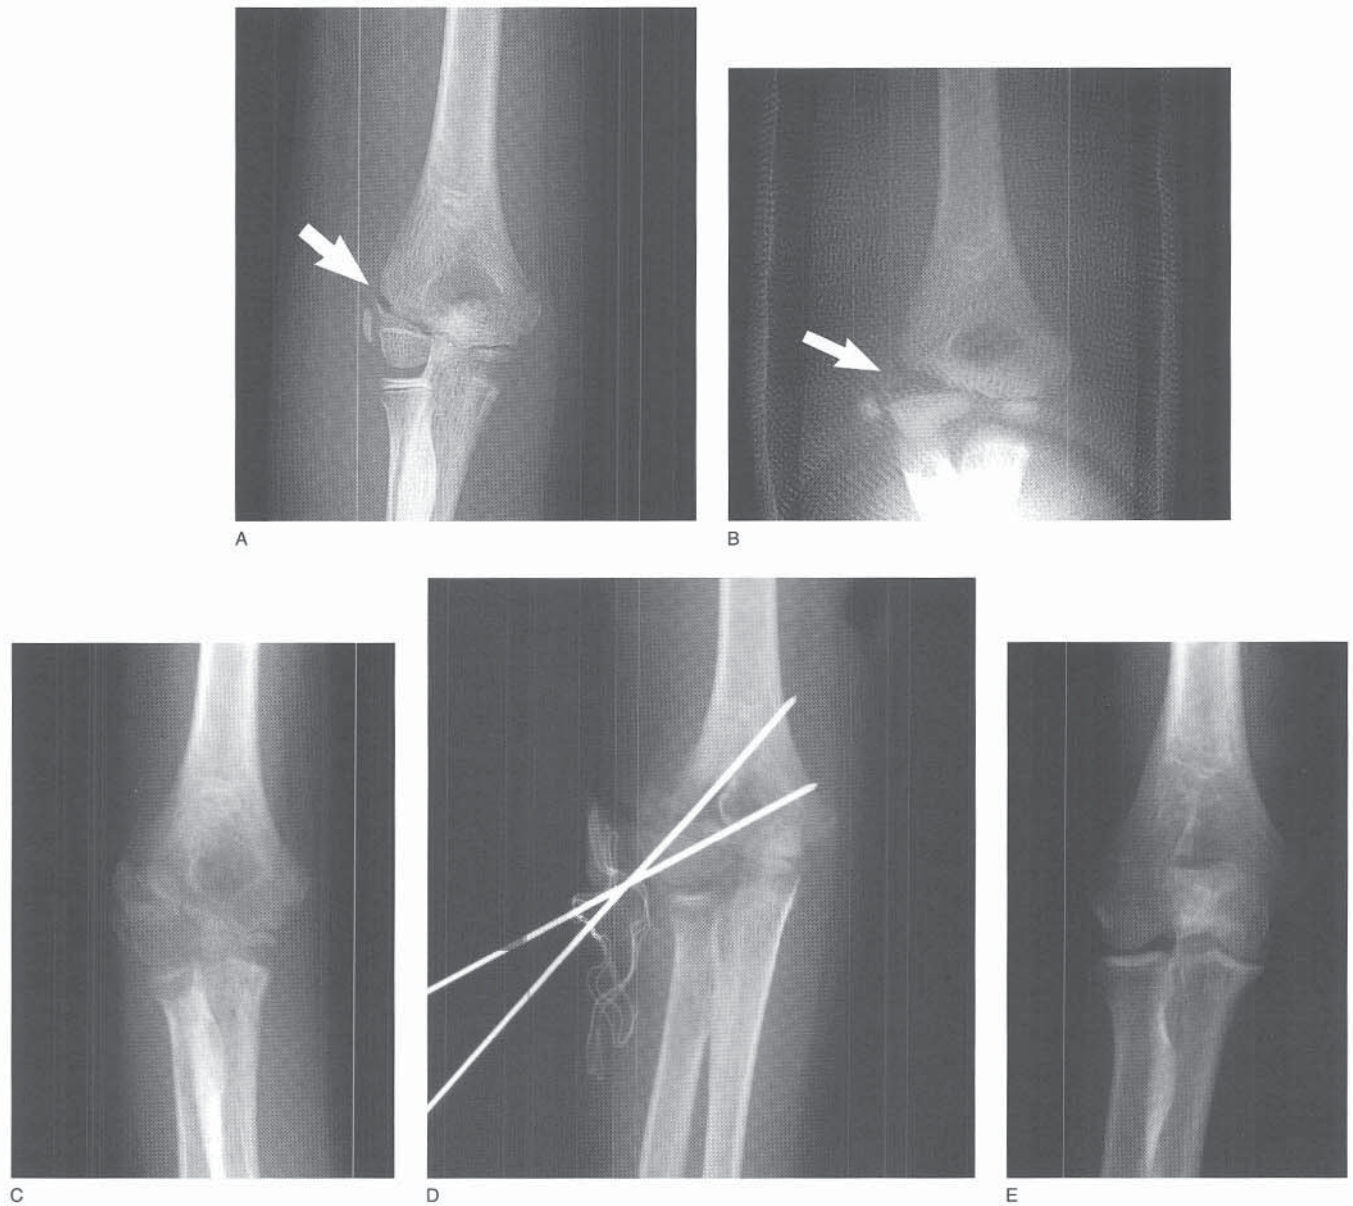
Radiographic example of a minimally displaced lateral condyle, displacing with cast immobilization. A, AP radiograph at the time of injury showing a minimally displaced lateral condyle fracture (*arrow*). B, One week after injury, significant displacement of the fracture (*arrow*) had occurred. Cast immobilization was continued. C, Two months after the injury, a delayed union had developed. D, The delayed union was treated with open reduction and stabilization. Note the fracture was not reduced anatomically but was pinned in a position to provide maximal metaphyseal contact. E, Six years postoperatively the fracture has healed with minimal fishtail deformity of the distal humerus.
